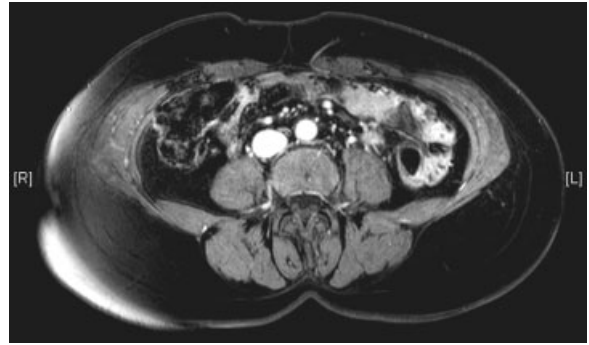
Abdominal magnetic resonance imaging angiography (axial view) demonstrating a large septocutaneous vessel, coursing medial to the left rectus abdominis muscle and arborizing toward the center of the flap.
